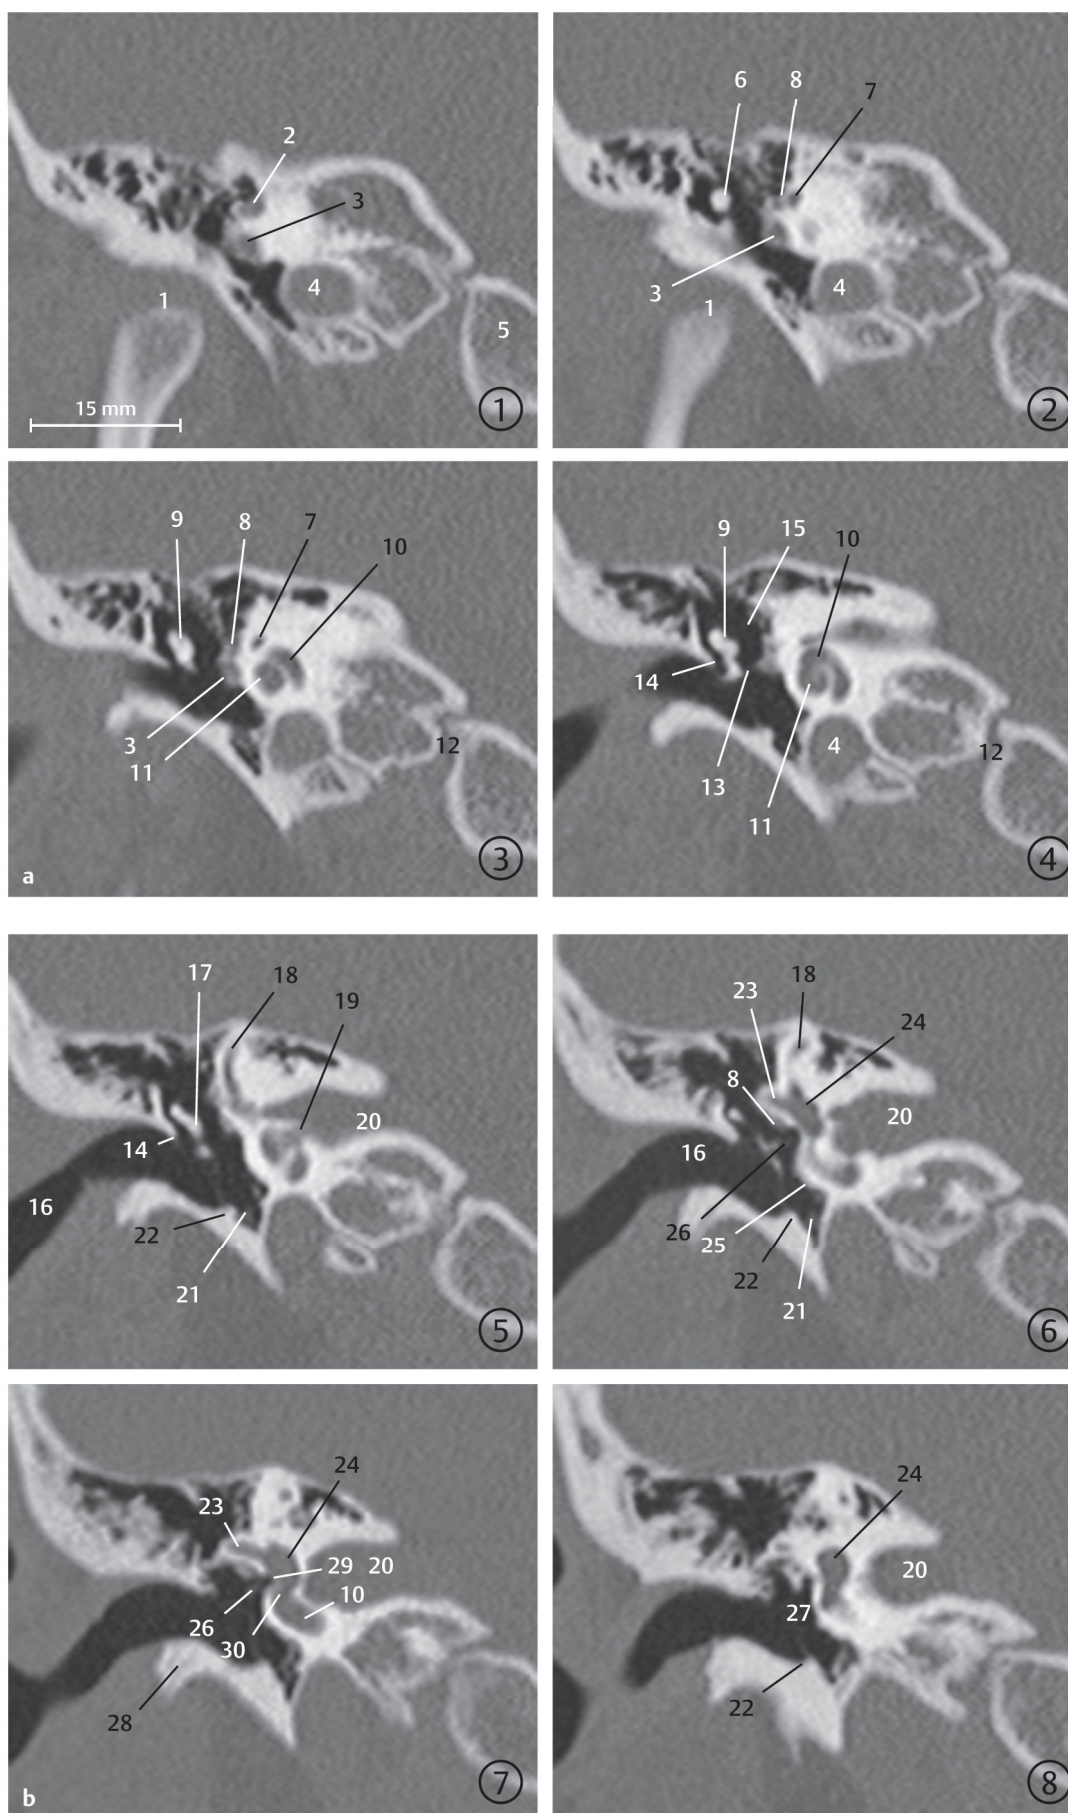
Petrous part of the temporal bone in coronal view. Coronal high-resolution CT images of relevant sections of the petrous part of the right temporal bone from anterior to posterior (slice thickness 0.625 mm). The encircled digit indicates the number of the slice in a series.
